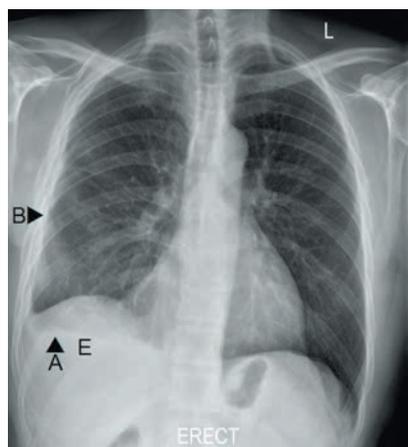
A chest radiograph showing a subpulmonic effusion (E), with lateral peaking (A) of the apparent hemidiaphragm, with associated features including a steep lateral and gradual medial slope of this apparent diaphragm. Additionally, there is loss of the costophrenic angle and the effusion is visible on the lateral aspect (B).
